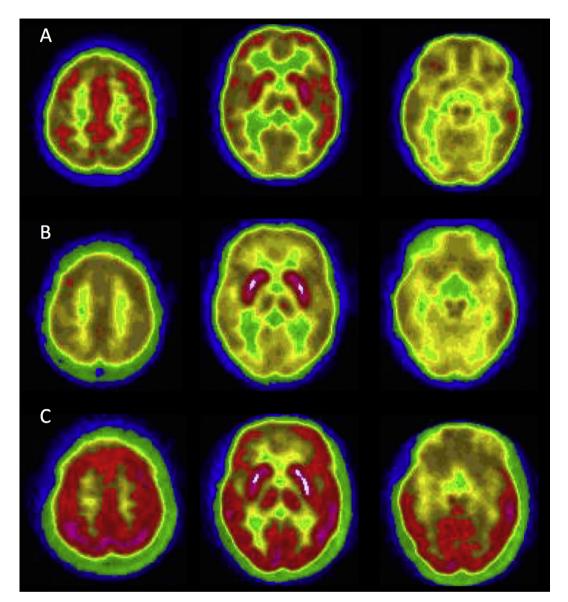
Cerebral FDG-PET features of patient 6. (A) At initial cerebral FDG-PET time point, patient 6 presented severe clinical status (mRS = 4) with movement disorder (dystonicus status), swallowing troubles and drowsiness. Initial cerebral FDG-PET, showed extensive cortical hypometabolism. (B) Second cerebral FDG-PET, after clinical worsening despite immunotherapy (mRS = 5), showed deterioration of brain metabolism with severe extensive cortical hypometabolism and basal ganglia hypermetabolism. (C) Third cerebral FDG-PET, after intra-thecal methotrexate injection and clinical mild improvement (mRS = 4), showed partial improvement of cortical metabolism but persistent basal ganglia hypermetabolism.
